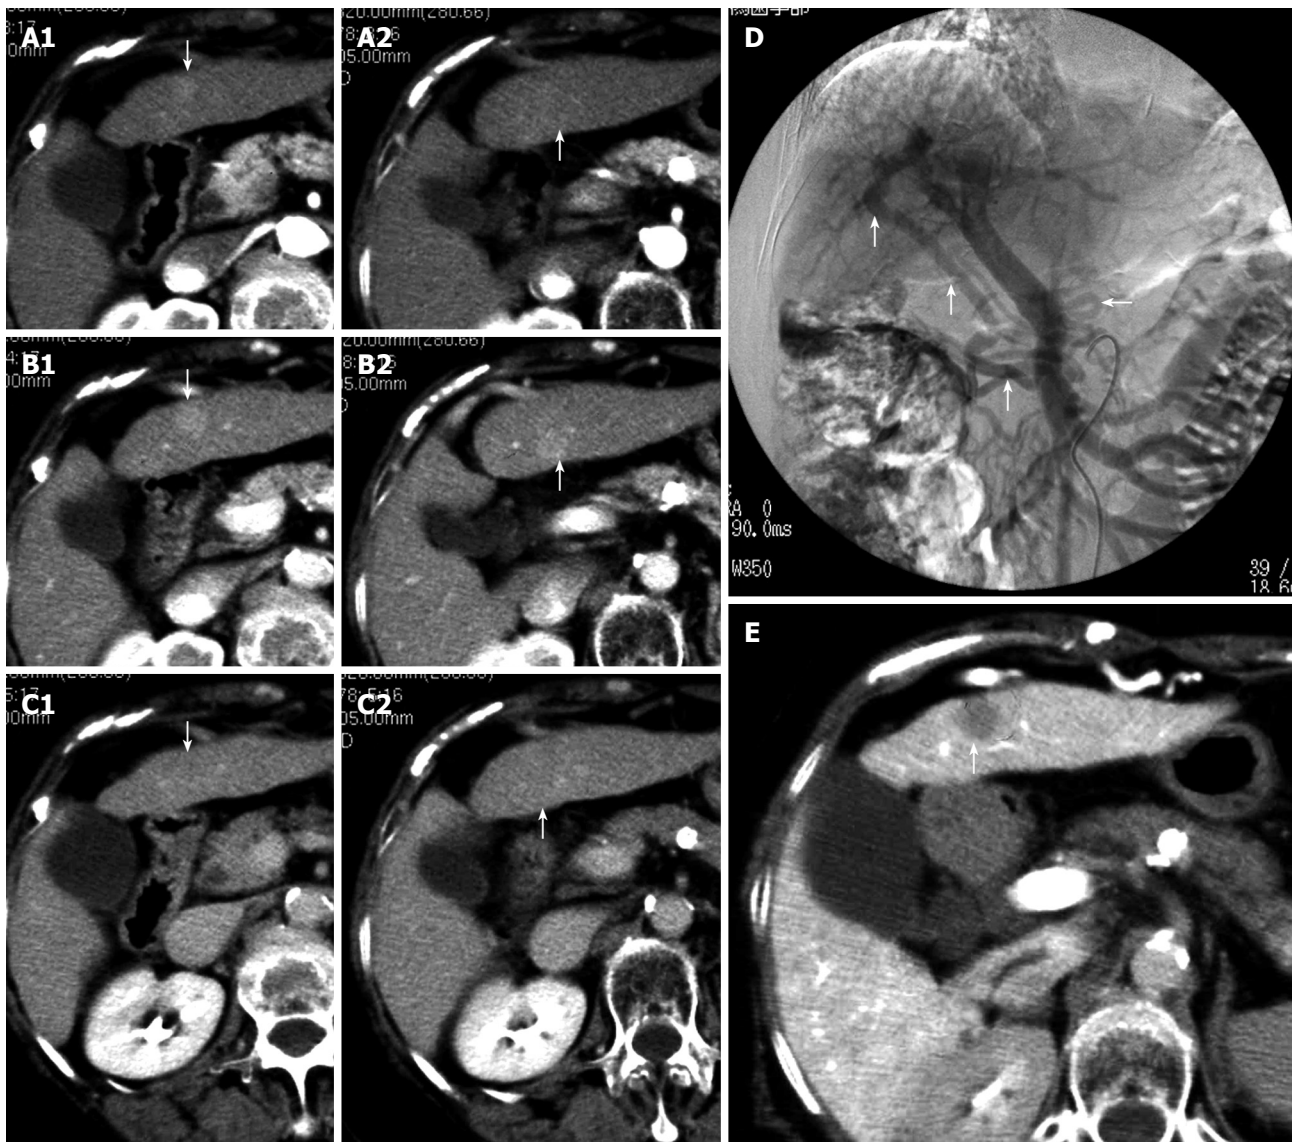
Dynamic computed tomography findings at the onset of double cancer with hepatocellular and cholangiocellular carcinomas. Two tumors, ~1 cm in diameter, were detected on the ventral and dorsal sides of S3. Arrows indicate the tumors (A1, A2 arterial phase; B1, B2 parenchymal phase; C1, C2 delayed phase). Angiographic findings at the onset of double cancer; D: A superior mesenteric arterial angiogram showing a large shunt through the epigastric vein during the portal phase (the arrows); E: Computed tomography during arterial portography (CTAP) showing a ~1 cm defect on the ventral side of S3 (the arrow), which was diagnosed as a classic hepatocellular carcinoma. No defect can be seen on the dorsal side of S3.
